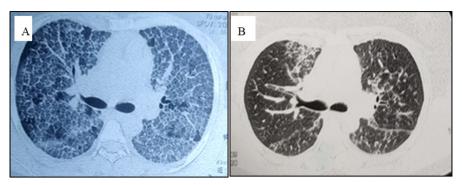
HRCT chest showing diffuse ground glass opacities and consolidation with superimposed smooth interstitial thickening giving "crazy paving" pattern at presentation (A), significant clearing of GGO's and interlobular septal thickening after three sessions of WLL (B).
